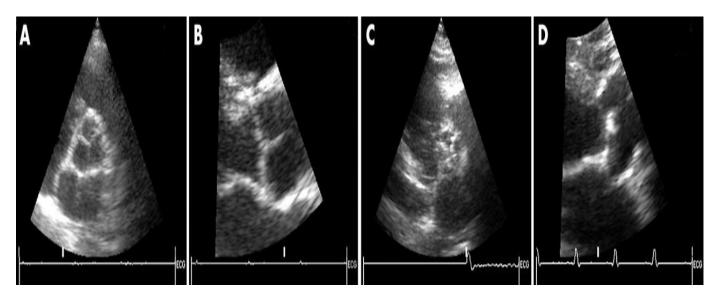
Echocardiography for AVS case. A) indicated standard cusps in the parasternal short axis, B) showed enlarged image in the parasternal long axis, while C) showed sclerotic cusps in the short axis, and D) showed sclerotic cusps in the long axis [8]
